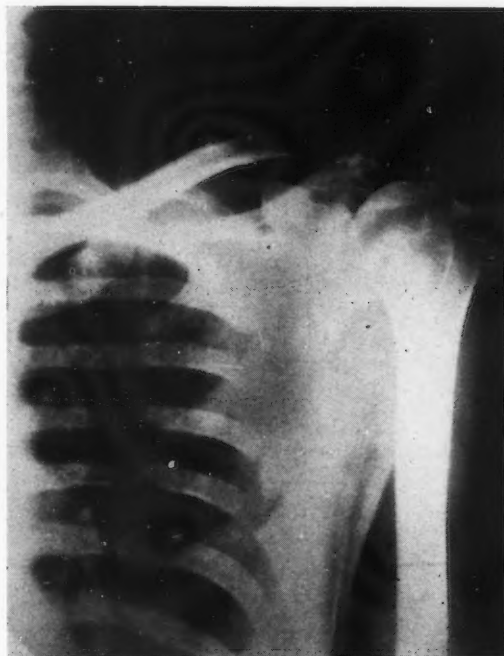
Anterior-posterior x-rays of the left acromion demonstrating cystic changes in the acromion process.
